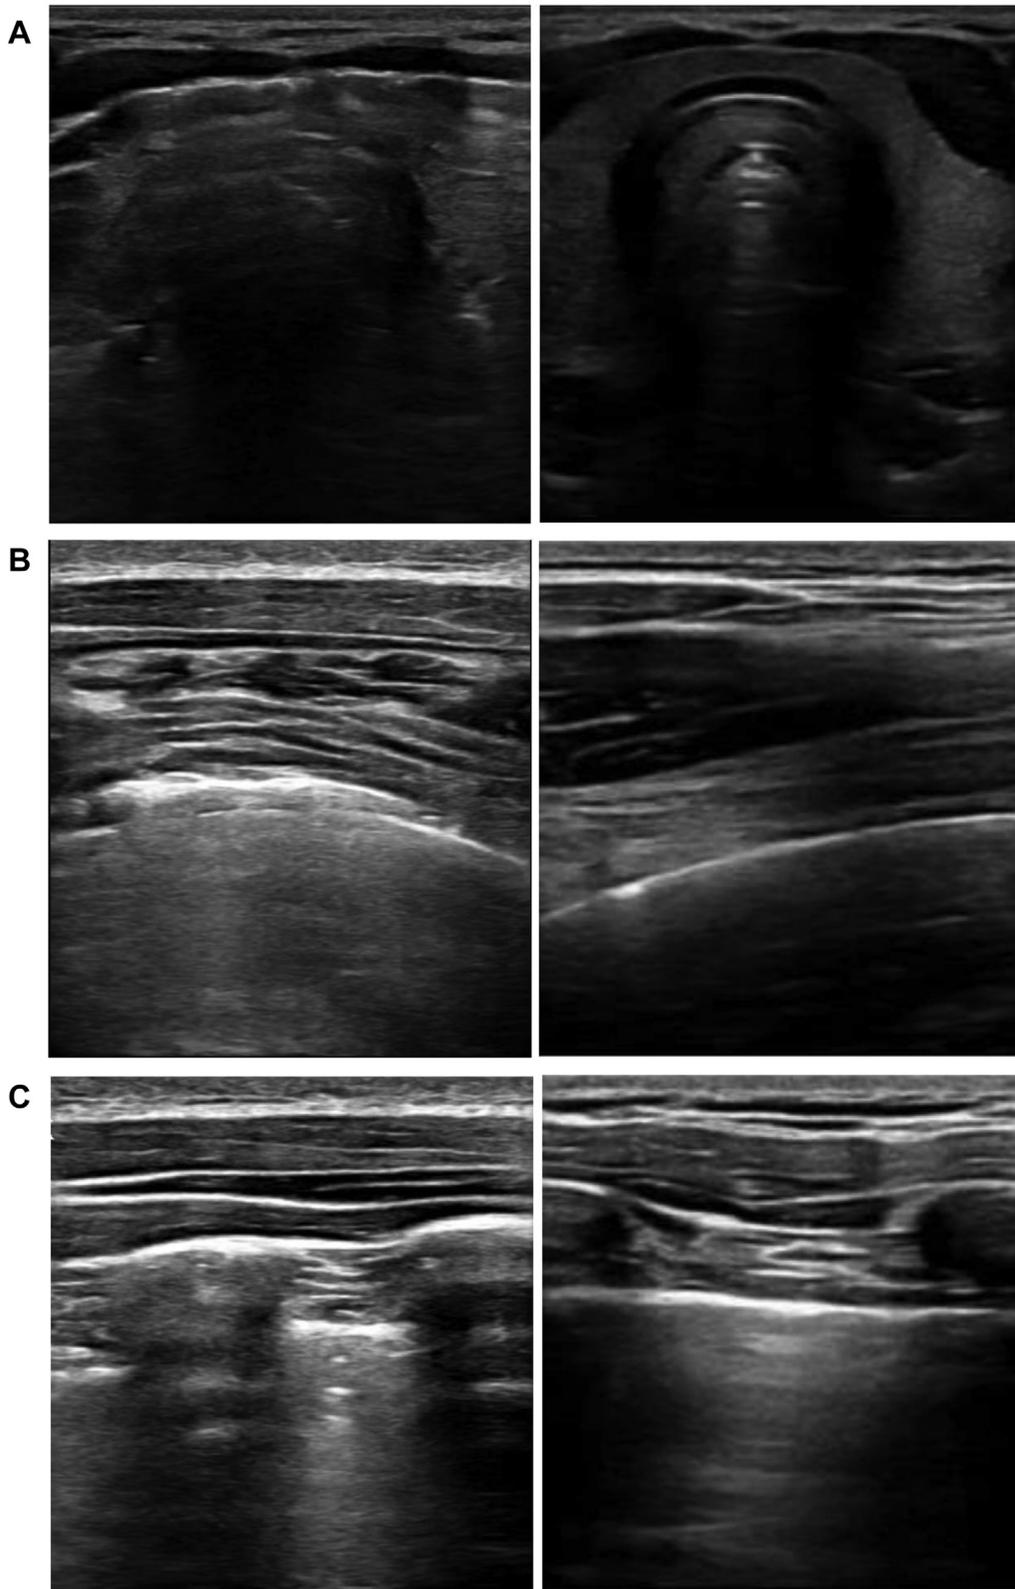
A, The ultrasound of the neck on the axial view of the thyroid gland. On the left, the acoustic barrier makes visualization of the “butterfly image” of the thyroid difficult due to the air into the soft tissues of the neck; on the right, following 1 month from hospital admission, the complete resolution of subcutaneous emphysema makes the butterfly image visible. B, The lung ultrasound on the axial view. On the left, the “gaseous band-like” appearance makes complete visualization of the underlying pleural line and regular A-lines difficult due to the air present among the intercostal muscles; on the right, following 1 month from hospital admission, the complete resolution of the pneumomediastinum allows visualization of the underlying tissues and physiological artifacts. C, The lung ultrasound on the sagittal view in the paravertebral site. On the left, the pathological condition due to the gaseous band-like appearance as previously indicated; on the right, following 1 month from hospital admission, the regular ultrasonography pattern.
